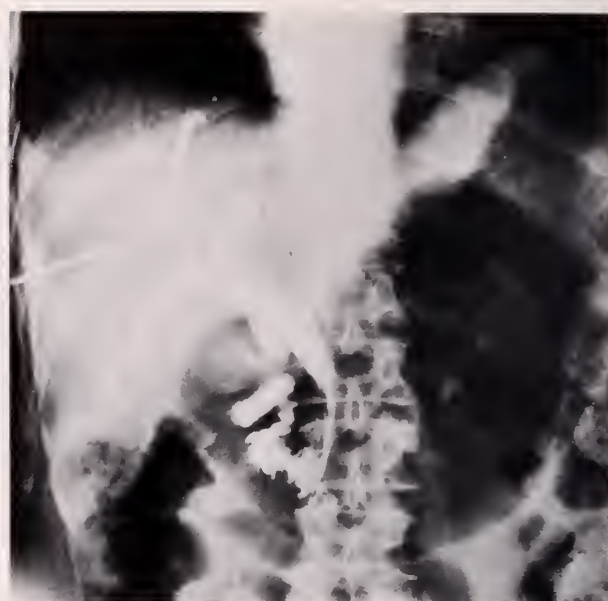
A radiograph performed after percutaneous placement of a biliary drainage catheter. The common bile duct and several intrahepatic radicles are dilated and filled with contrast material. The catheter, placed percutaneously, traverses liver substance, courses through the common bile duct and into the duodenum. There are side holes above the obstruction (caused by pancreatic carcinoma) and below the obstruction in the duodenum.
